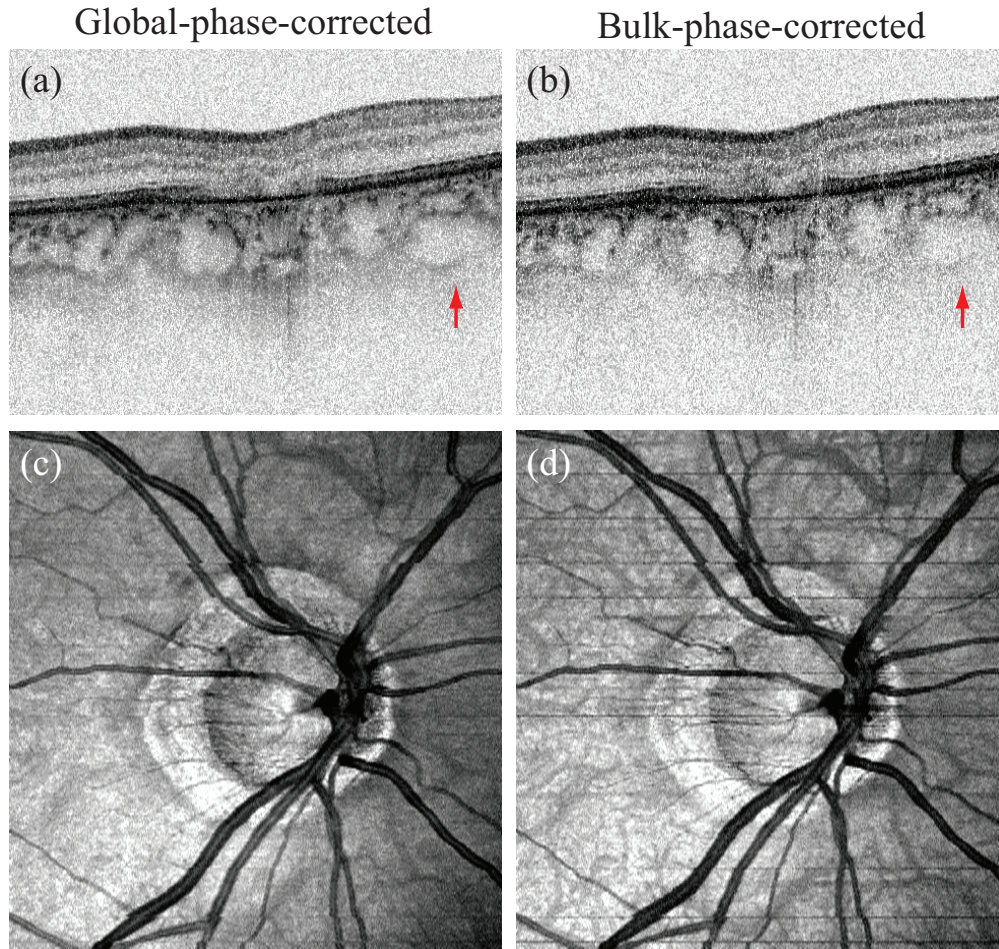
The comparison between global- and bulk- phase-corrected sensitivity-enhanced scattering OCTs. (a) and (c) are a B-scan and *en face* projection of sensitivity-enhanced OCTs with global-phase correction, and (b) and (d) are those with bulk-phase correction. (Source: Ju et al. *Advanced multi-contrast Jones matrix optical coherence tomography for Doppler and polarization sensitive imaging* [90])
